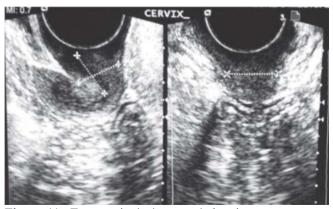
Transvaginal ultrasound showing measurement of the cervix. The cervix measured 1.3cm x 1.5cm x 1.3cm.
